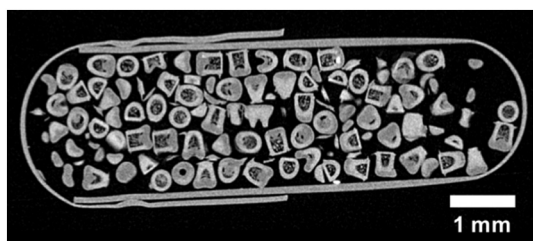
X-ray μ CT image of a gelatine capsule filled with loaded and coated D-MCs.
